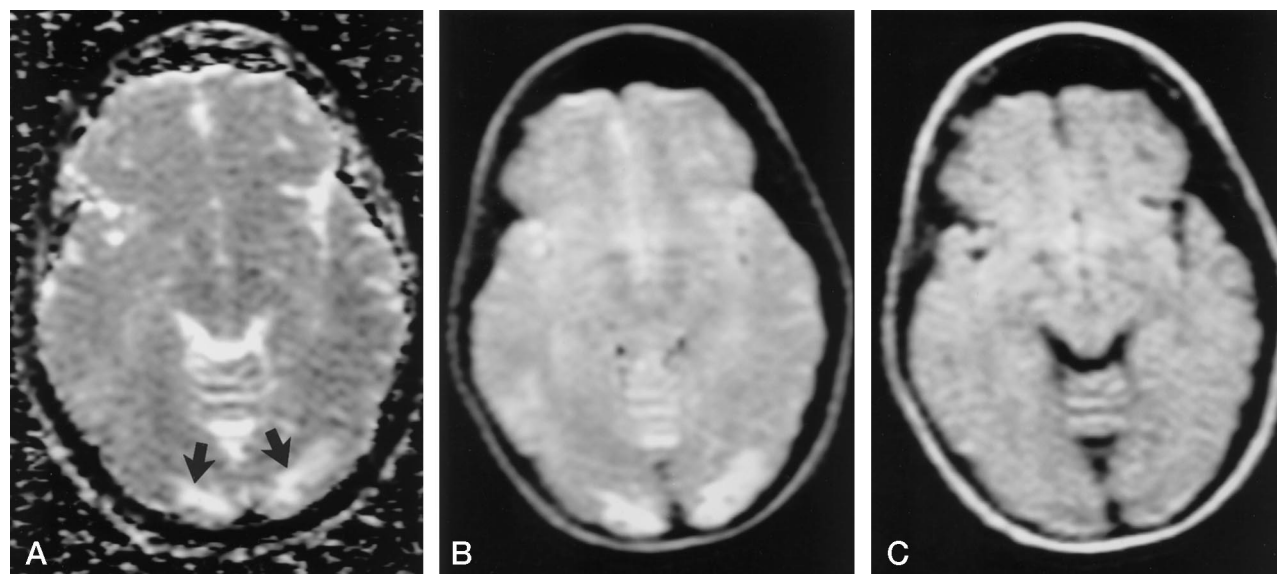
Axial MR images in a patient (case 1) with hypertensive encephalopathy. She had been treated for Legionella pneumonia and was extubated, but she became anxious and hypertensive (maximum blood pressure, 238/124) after experiencing difficulty breathing as a result of mucus plugging. She had a generalized seizure the next morning.
